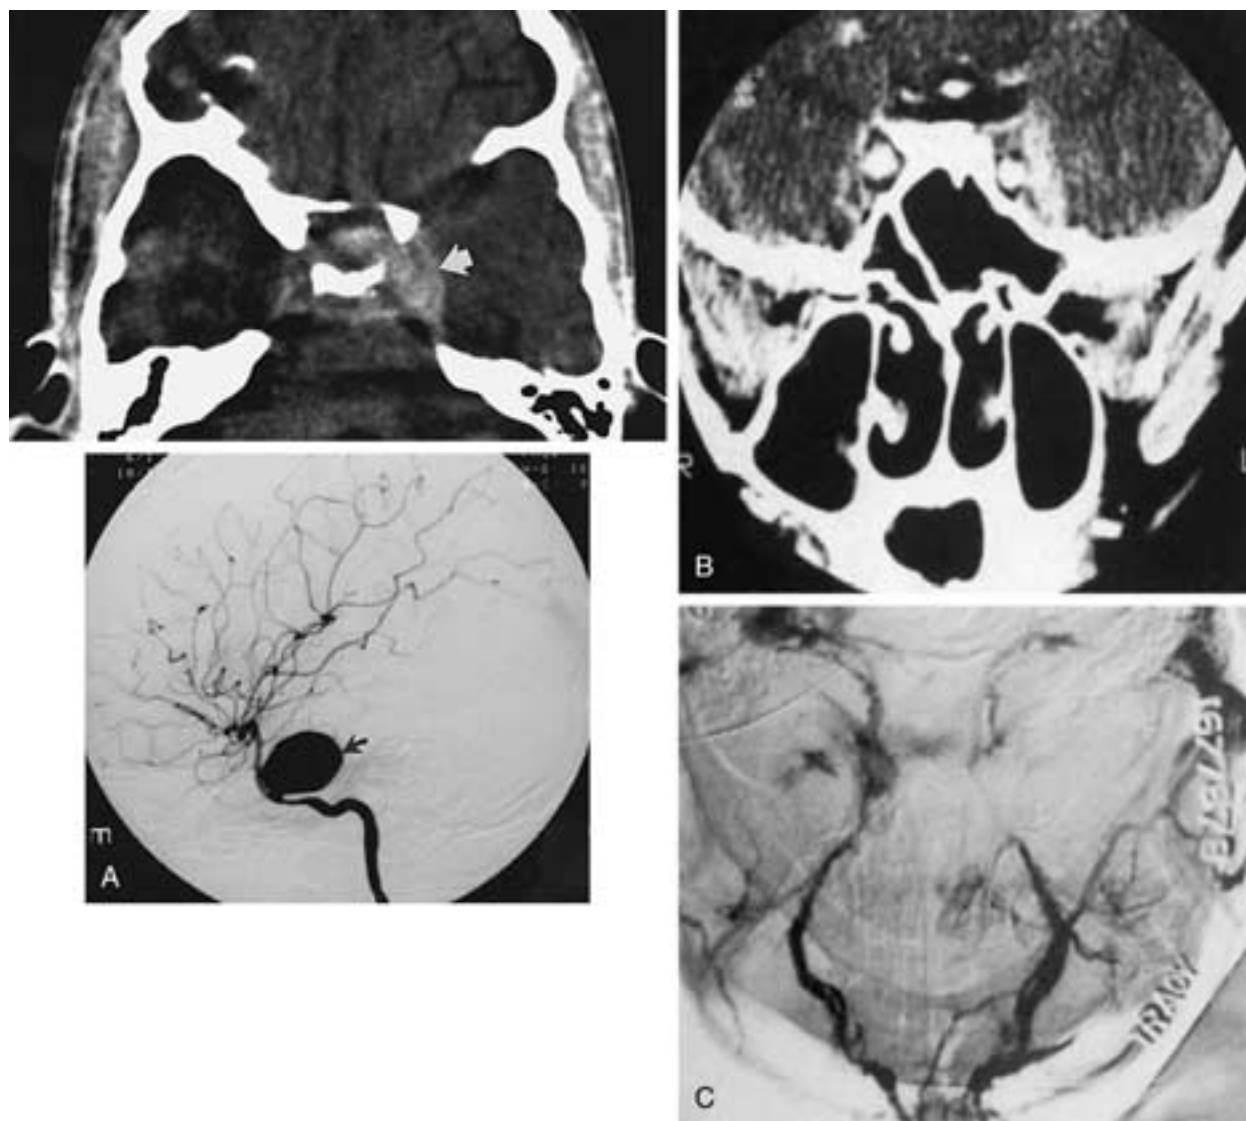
A, Mycotic (septic) aneurysm. 1, Enhanced axial CT scan shows an enhancing mass (arrow) in the left cavernous sinus related to a mycotic artery. 2, Lateral angiogram shows a large aneurysm (arrow) of the cavernous portion of the internal carotid artery. (From Eustis HS et al. MR imaging and CT of orbital infections and complications in acute rhinosinusitis. *Radiol Clin North Am* 1998;36:1165–1183.) B, Bilateral cavernous sinus thrombosis. Coronal CT section through the cavernous sinus following bolus injection reveals opacification of the internal carotid arteries bilaterally. The cavernous sinus reveals decreased attenuation in keeping with cavernous sinus thrombosis. Note enhancement of the dura bordering the left cavernous sinus. C, Right cavernous sinus thrombosis. Orbital venogram in the axial projection shows obstruction of the cavernous sinus on the right, secondary to thrombosis. Note the filling of the normal left cavernous sinus. (B and C from Weber AL, Mikulis DK. Inflammatory disorders of the paraorbital sinus and their complications. *Radiol Clin North Am* 1987;25:615–630.)
